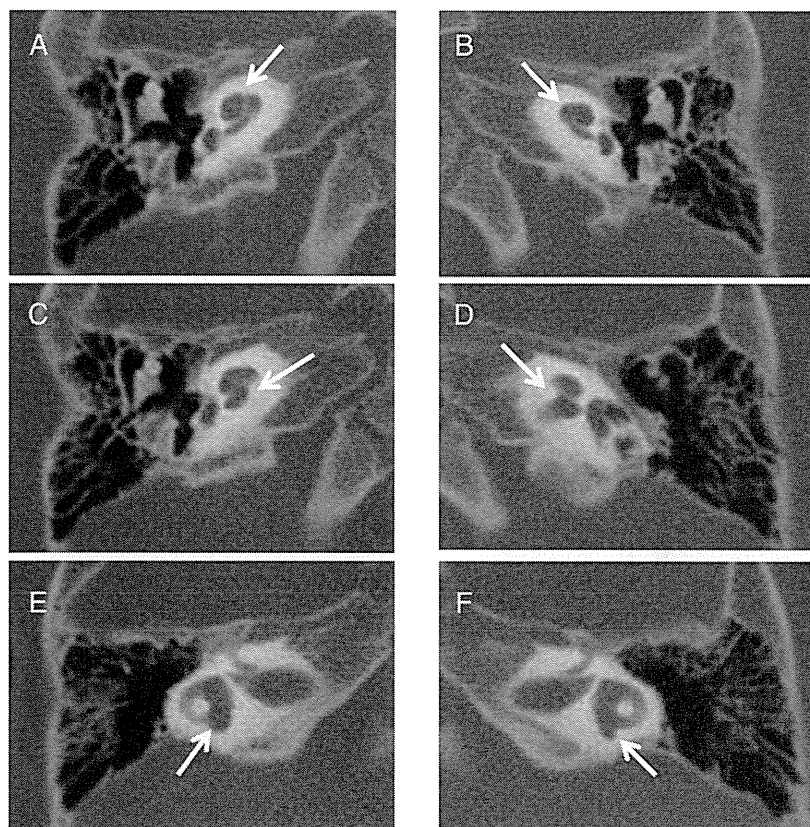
CT of the temporal bone of the patient. The right ear is shown in the left column (A, C, E), and the left ear is shown in the right column (B, D, F). Each row shows the same level of horizontal section of the inner ear. Bilateral inner ear malformations of this patient are shown in these images. Hypoplasia of the bilateral cochleae (A, B; arrows). Atresia of the bilateral cochlear nerve canals (C, D; arrows). Enlarged vestibules with potential anlagen of the posterior semicircular canals (E, F; arrows).
